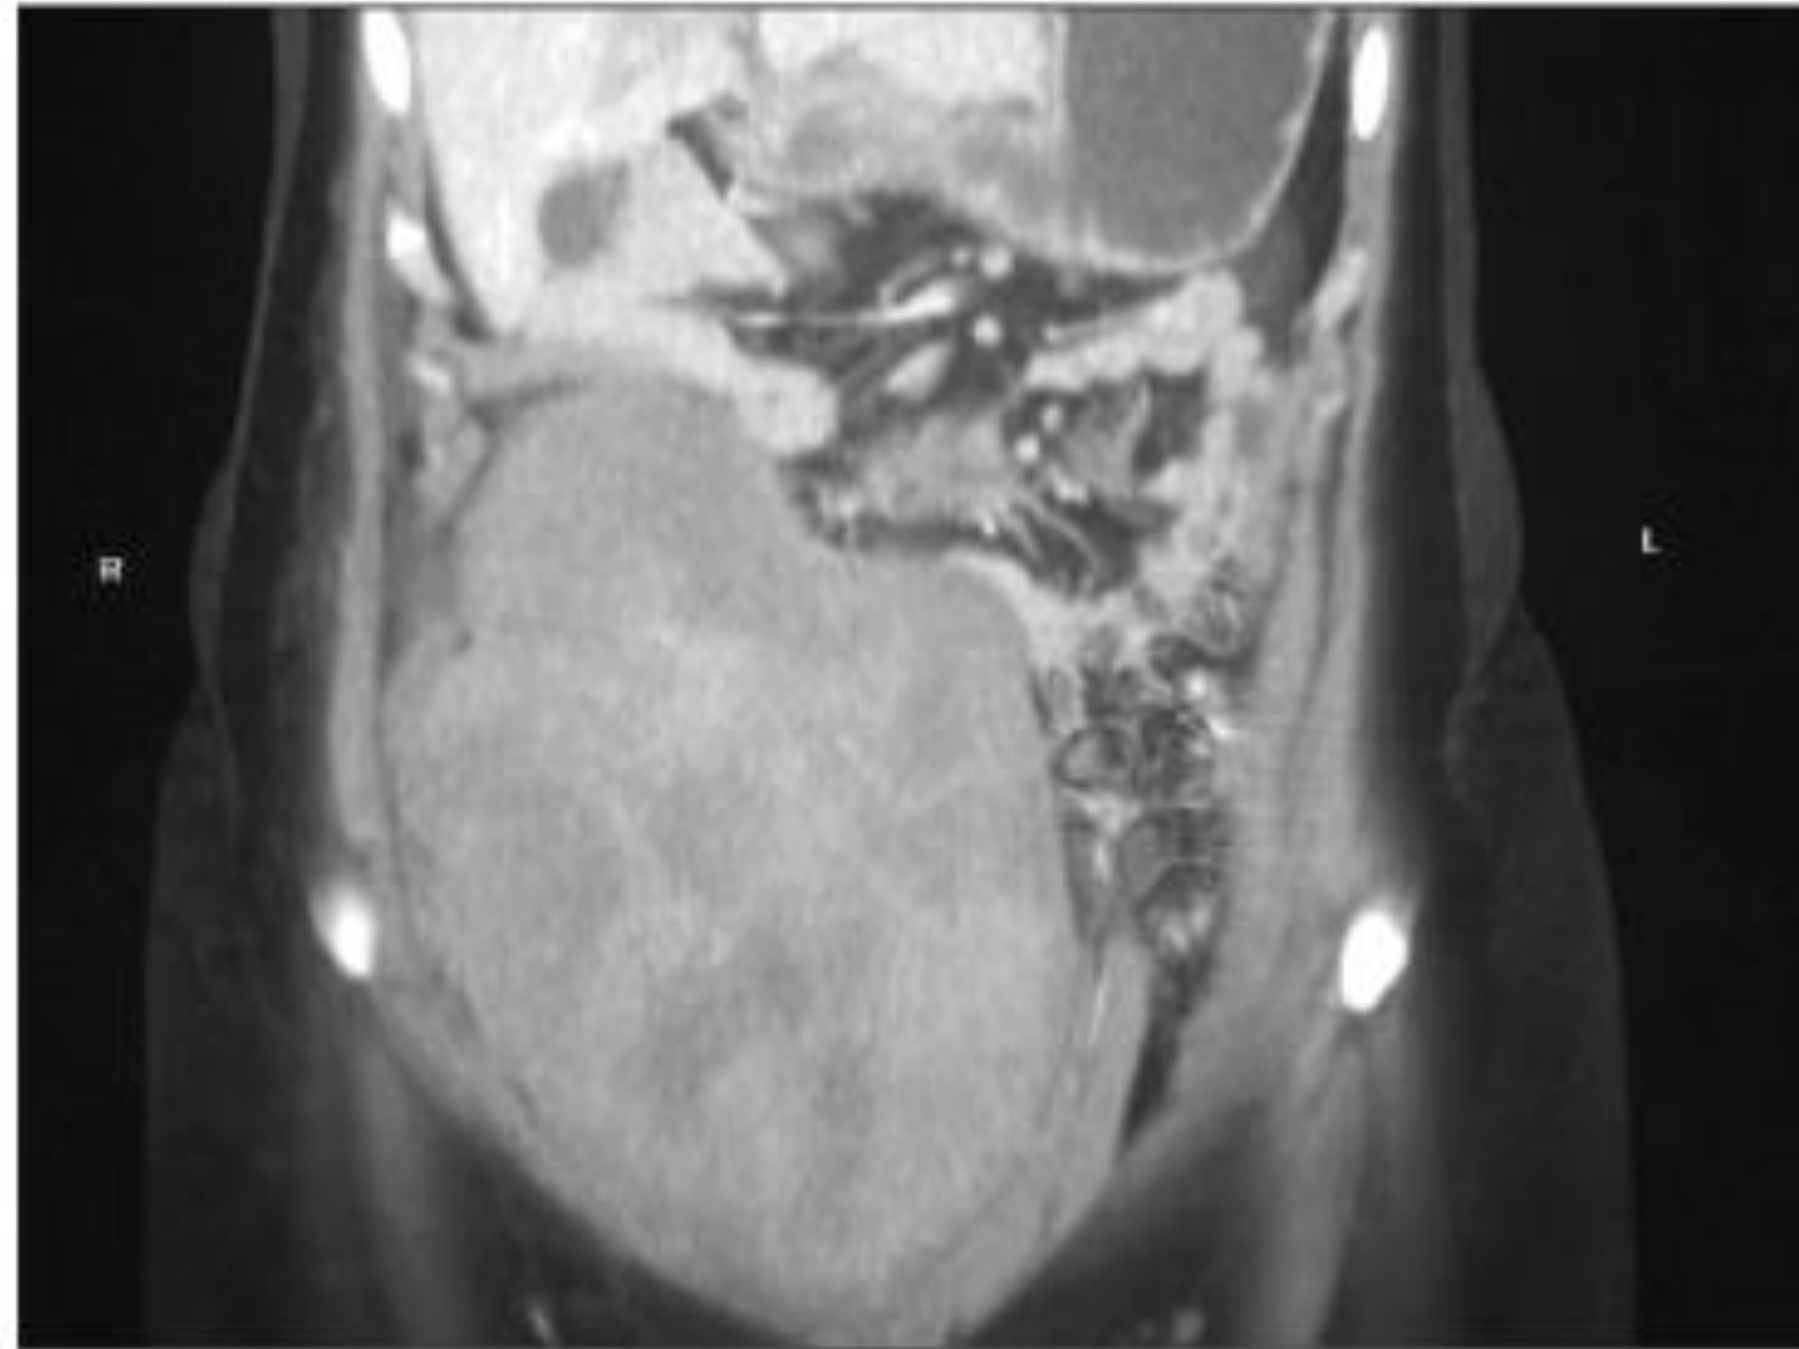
CT scan showing a large desmoid tumor of the left rectus abdominis.
